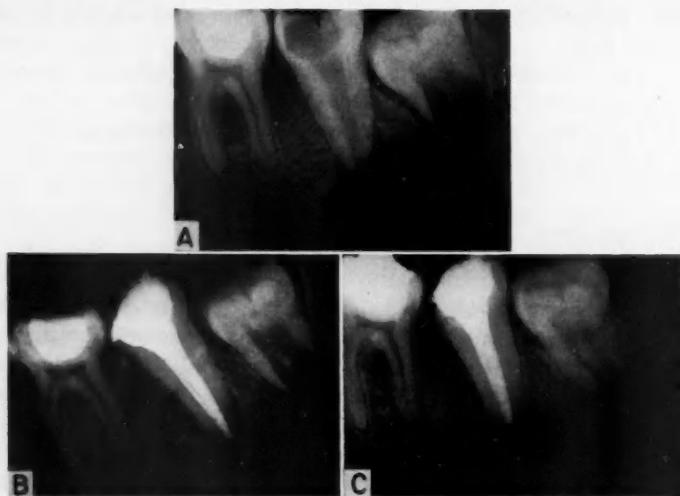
Lower molar with gangrenous pulp and circumscribed periapical radiolucency. A, Before treatment; B, immediately after treatment; C, 14 months after treatment.
